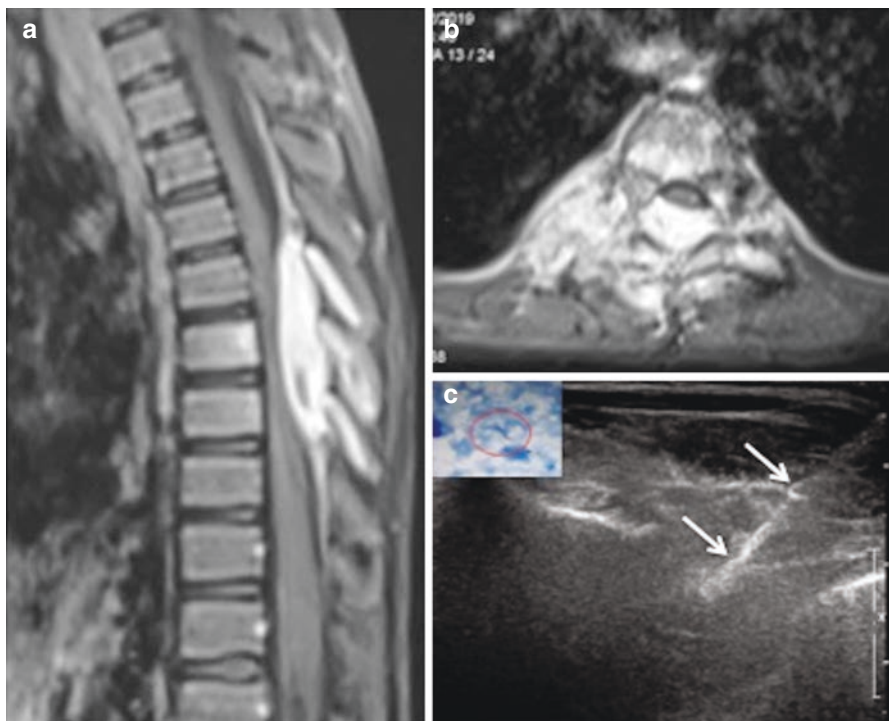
Ultrasound-guided fine needle aspiration of tuberculous inflammatory lesion centered at the posterior arch elements of the dorsal vertebrae with contiguous involvement at three spinal levels with associated paravertebral and intraspinal extradural soft tissue component evident on sagittal (a) and axial (b) post-contrast T1 weighted MR images. Needle in situ (arrows) targeting the lesion. Acid fast bacilli evident on the aspirate slide in Fig. C (inset)
